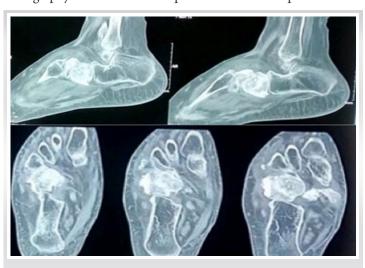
Computed tomography scan of the foot shows an expansile lesion located eccentrically in the inferomedial aspect of the cuboid bone.
